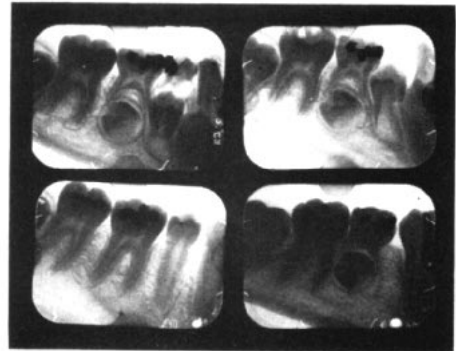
Normal development and eruption after serial extraction. Right lower posterior apical x-rays. Top left, age 8:5, Top right, age 10:3, Bottom right, age 11:3, Bottom left, age 13:10.
